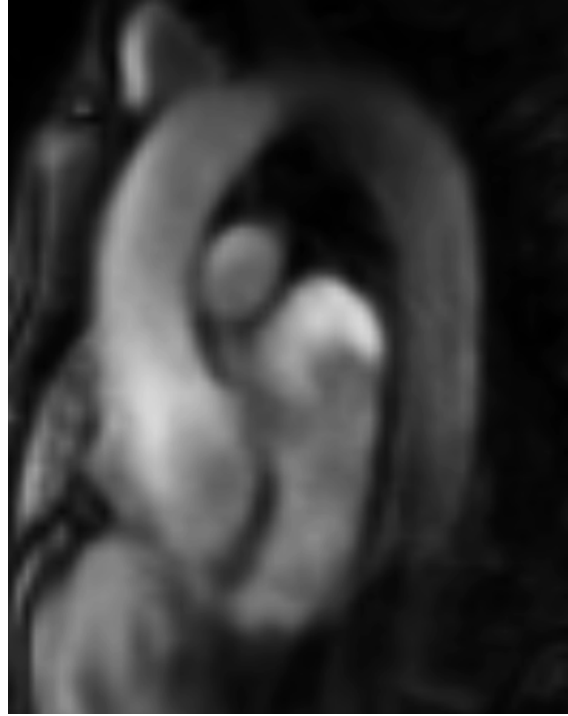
Visualization of patient D1 aorta with MRI using Mass.
